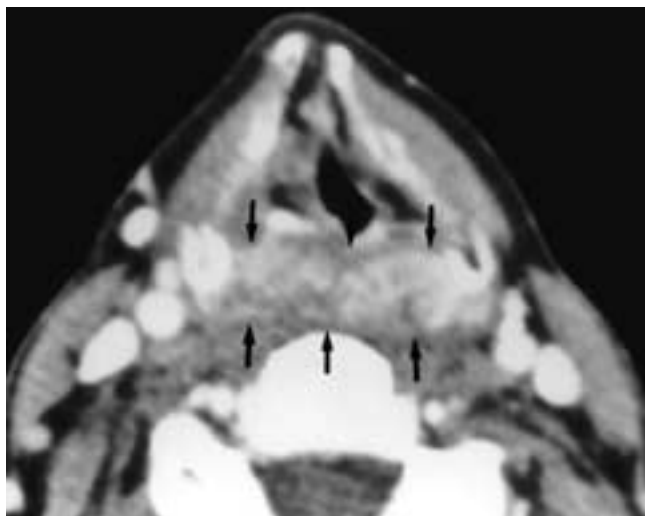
Axial contrast-enhanced CT scan shows a squamous cell carcinoma involving the posterior pharyngeal wall (arrows).
